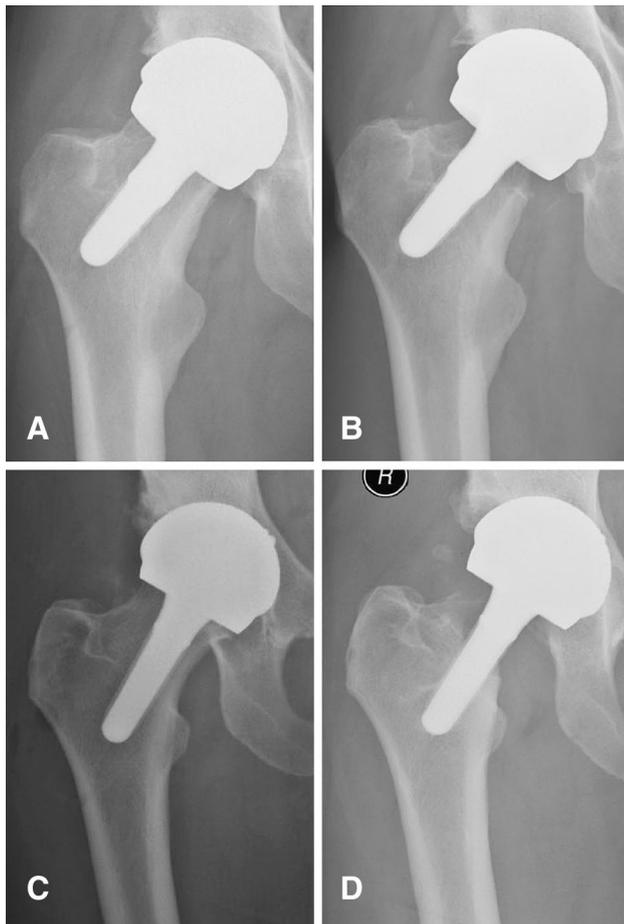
Plain hip radiographs of two patients taken immediately postoperatively (A and C) and at 3 years (B) and 6 years (D) followup showing femoral neck osteolysis. The patient in A and B had the VST version, and the patient in C and D had the V1 version of the BMHR.
